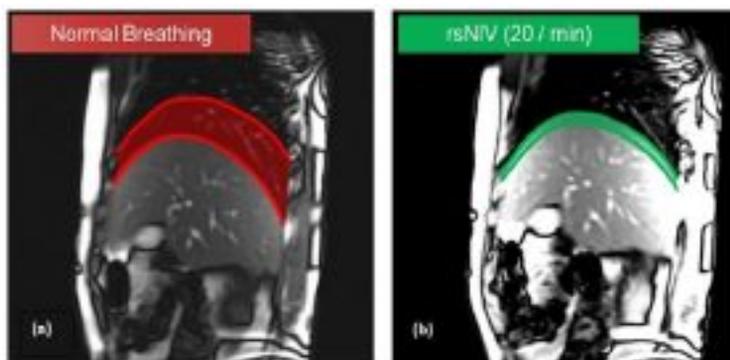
Sagittal cinematic MRI scans showing the range of respiratory motion in (a) normal breathing and (b) rapid shallow non-invasive ventilation (rsNIV) at 20 breathes per minute for a healthy volunteer.
